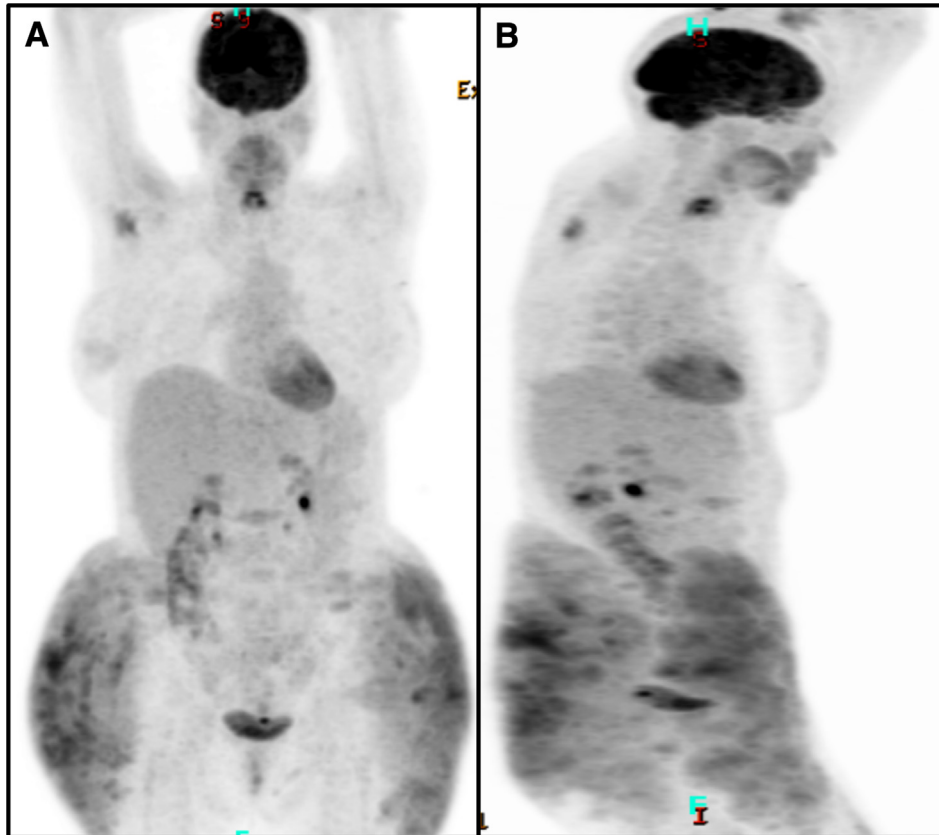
Total body fluorodeoxyglucose positron emission tomography (PET)/CT scan. Panel A: Anteroposterior view. Panel B: Right lateral view. Noted diffuse moderate FDG uptake in the subcutaneous adipose tissue of bilateral gluteal regions greatest laterally extending inferiorly to the level of the hips and upper thighs, measuring on the order 31 cm in superior to inferior extent bilaterally. The left-side area has a SUV max of 4.9, and the right-side area has SUV max of 5.4.
